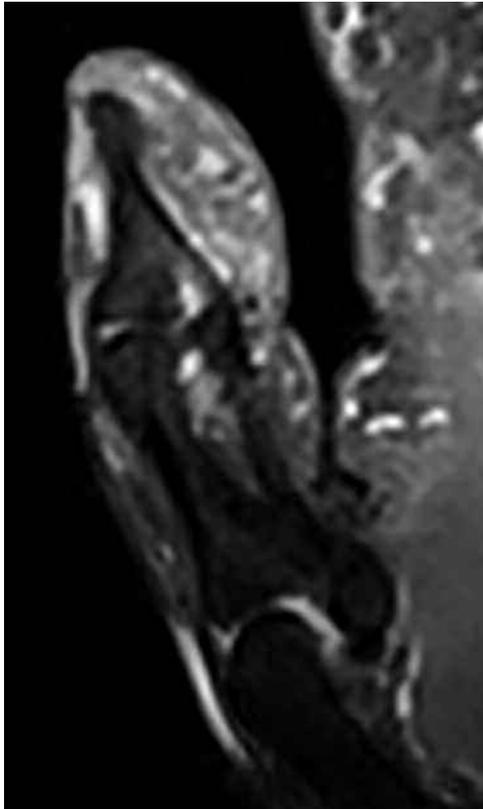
Low-field new generation magnetic resonance imaging of the distal phalanx, short-tau inversion recovery (STIR) sagittal, standard wrist coil. In the STIR image, thumb's normal bone and subcutaneous tissue appear dark due to suppression of fat signal.
